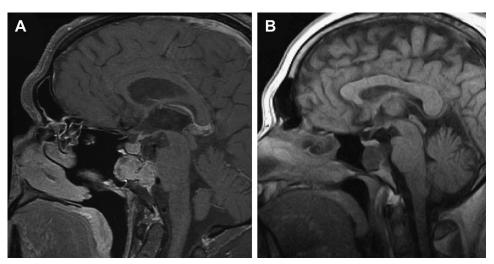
MRI of chordoma. Preoperative sagittal images of (A) a chordoma that showed intradural invasion at surgery, and (B) a chordoma that proved to be entirely extradural at surgery.
